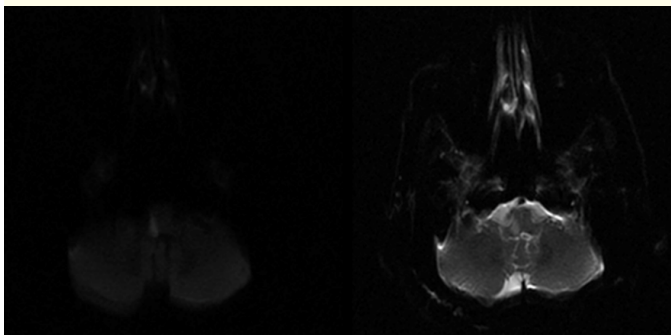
MRI of the skull in an axial plane at the level of the posterior fossa where the T2 effect is demonstrated in DWI and in ADC, being hyperintense in both.
